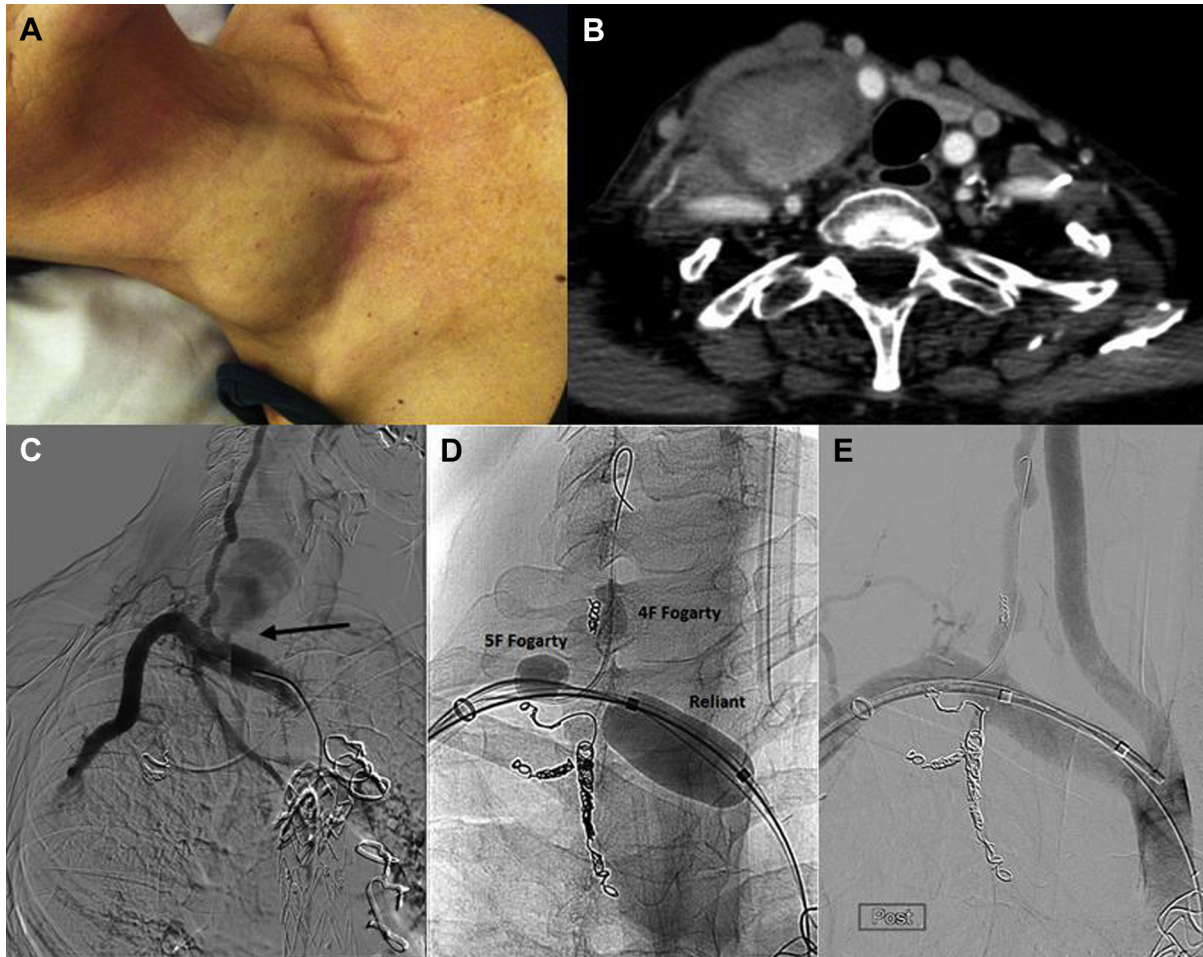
The patient presented with a pulsating mass of around 10 cm on the right side of the neck. B. The computed tomography angiography scan showed a large pseudoaneurysm, with an apparent connection with the right subclavian artery (RSA). C. Diagnostic angiography was performed from the groin to determine the origin of the pseudoaneurysm. A clear blush is visible next to the arrow. D. Angiogram made during the procedure, showing the coils in the right internal mammary artery and other side branches as well as the balloons inflated in the right vertebral artery (RVA; 4F Fogarty) and in the proximal (Reliant) and distal part (5F Fogarty) of the RSA. E. An angiogram showing the result after surgical repair of the puncture hole. The coil that projects over the RVA is in fact in the ascending cervical artery.
